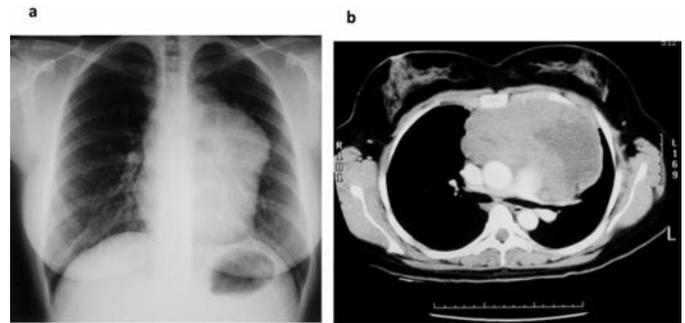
CXR (a) and CT (b) scan from a female patient presenting with PMBCL. Note is the large anterior mediastinal mass, with areas suggestive of central necrosis.
